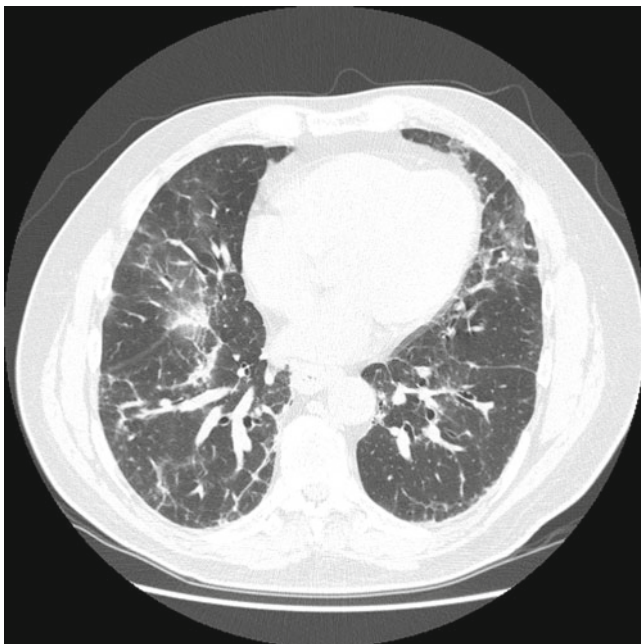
High resolution computed tomography of the chest showing signs of nonspecific interstitial pneumonitis
